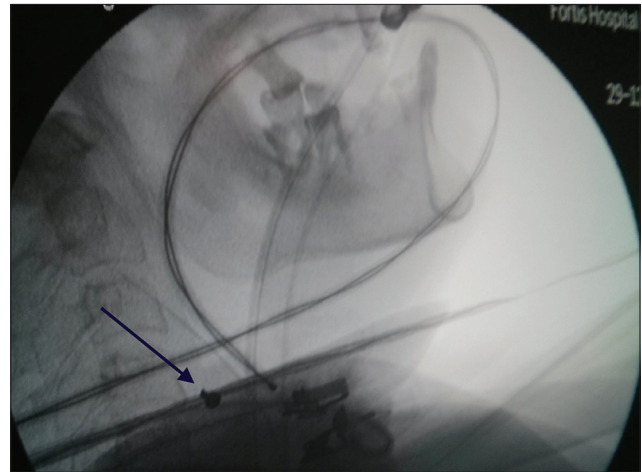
Radiograph showing the inner part of the nose stud located in the nasopharynx
